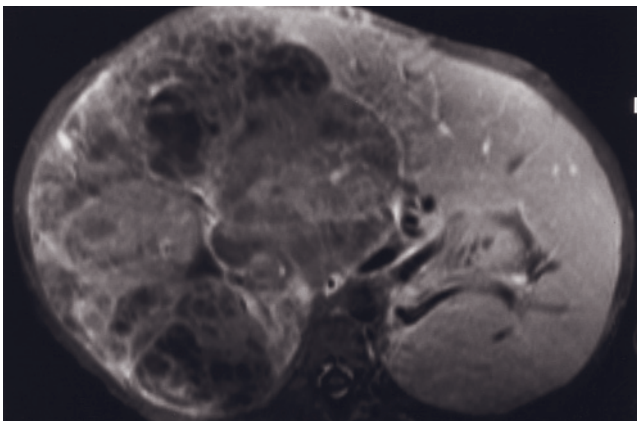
(Continued) renal cancer has developed from the cystic cancer (large arrow, *b*), and tumor thrombus expands the IVC (small arrows, *g*, *b*). T1-weighted fat-suppressed gadolinium-enhanced SE image shows the heterogeneous cancer, tumor thrombus, and small lymph nodes (arrow, *i*).
